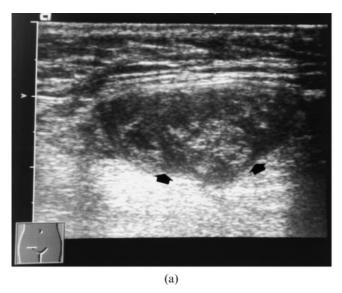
Mesh related infection. A 53-year-old man with ventral hernia repair and a polypropylene (PP) mesh inserted 7 years before. The patient was admitted to hospital due to epigastric pain and temperature. (a) Transverse ultrasound at the epigastric level. The PP mesh (long arrow) is surrounded by a purulent collection (*). In this patient apart from antibiotic treatment, puncture and drainage of the collection was performed under ultrasound guidance and an 8 French catheter was left under the PP mesh. (b) CT scan performed several days after drainage. Note the catheter in the abdominal wall. The PP mesh is not visible.
